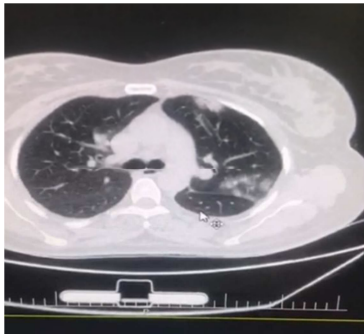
HRCT of the case 3 's mother with peripheral consolidation.
